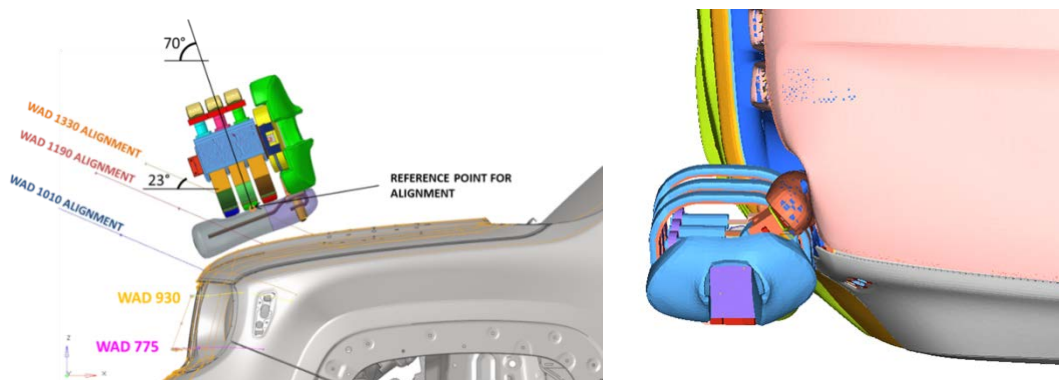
Examples of bonnet and grill TIPT tests against an SUV
